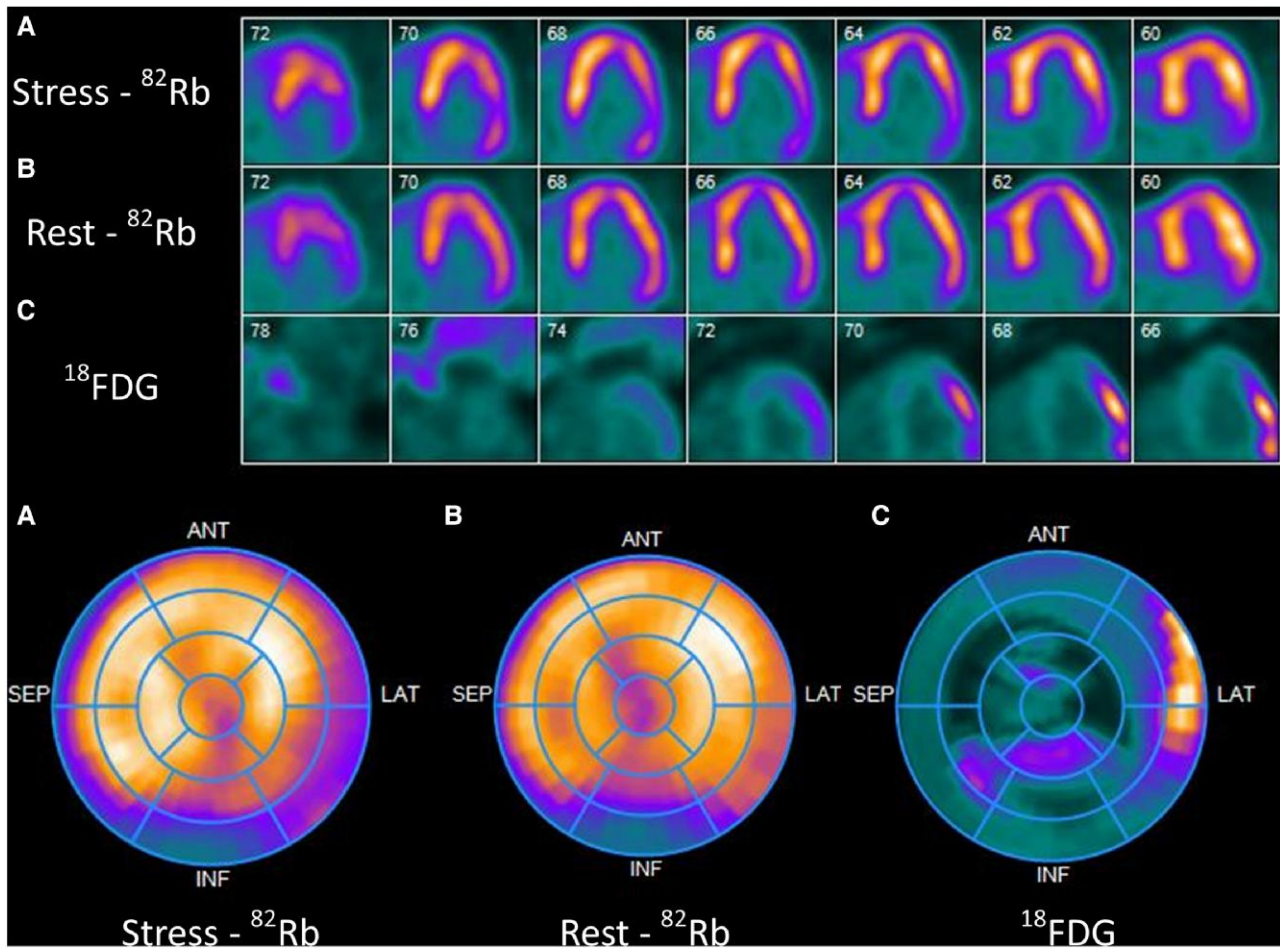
Stress/rest/viability imaging with ^{82}Rb . Stress (A) and rest (B) imaging shows a small, fixed defect in the inferior segments along with ischaemia in the lateral wall. (C) FDG images show scar in the inferior segments. FDG uptake in the lateral wall, corresponding to the ischaemic territory, is an example of ischaemic memory.
